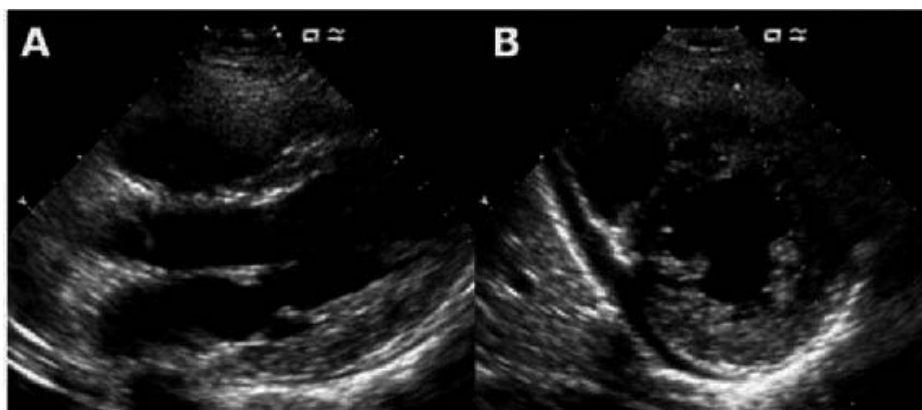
Echocardiogram on admission. Parasternal long axis view (A) and short axis (B) in diastole. There is an asymmetrical thickening of the posterior wall involving the posterior papillary muscle, and slight pericardial effusion. Adapted from reference number 38 with permission.
